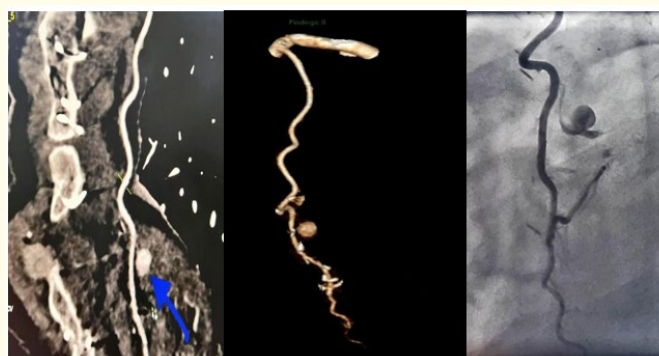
IMA branch pseudoaneurysm (A) CT-scan findings of vascular mass. (B) 3D CT angiogram reconstruction of the pseudoaneurysm arising from IMA branch. (C) Coronary angiography showing feeding branch of pseudoaneurysm IMA internal mammary artery.
